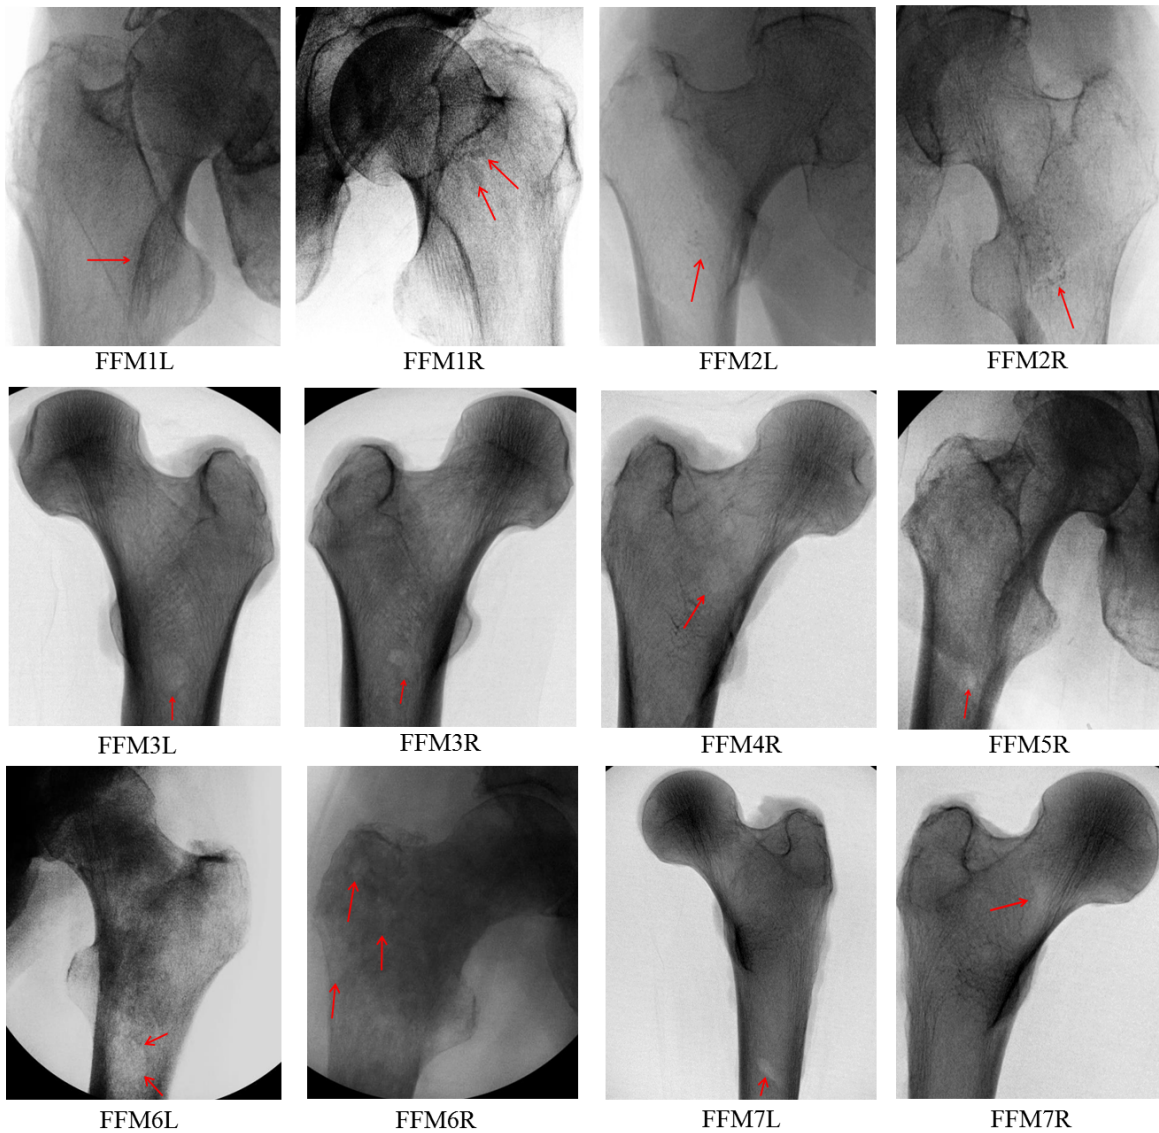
Radiograph images of femurs with suspected tumors (pointed to by arrows).
